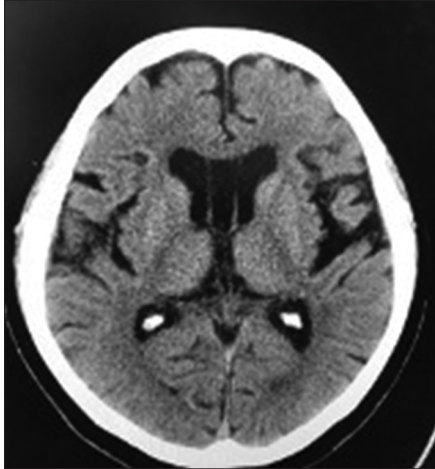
Head CT at admission. Slightly enlarged ventricles with cavum Vergae are visible.
